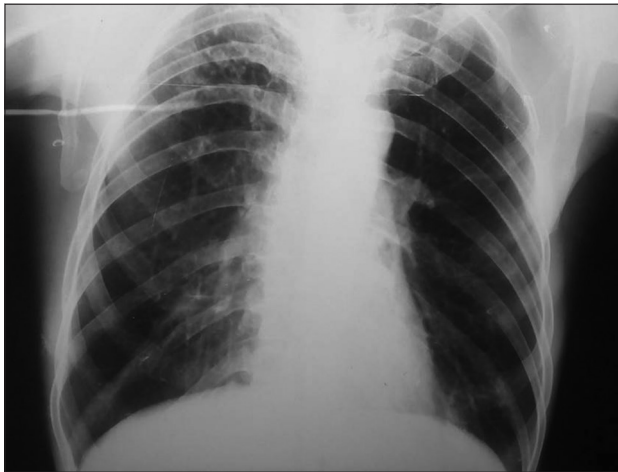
Chest radiograph revealing the involvement of bilateral upper lobes
